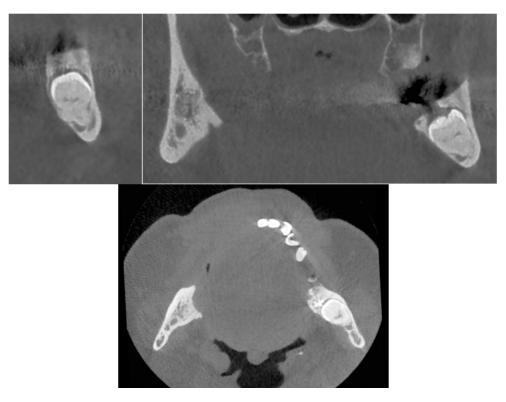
Cone-beam computed tomography (CBCT) frontal and axial views
